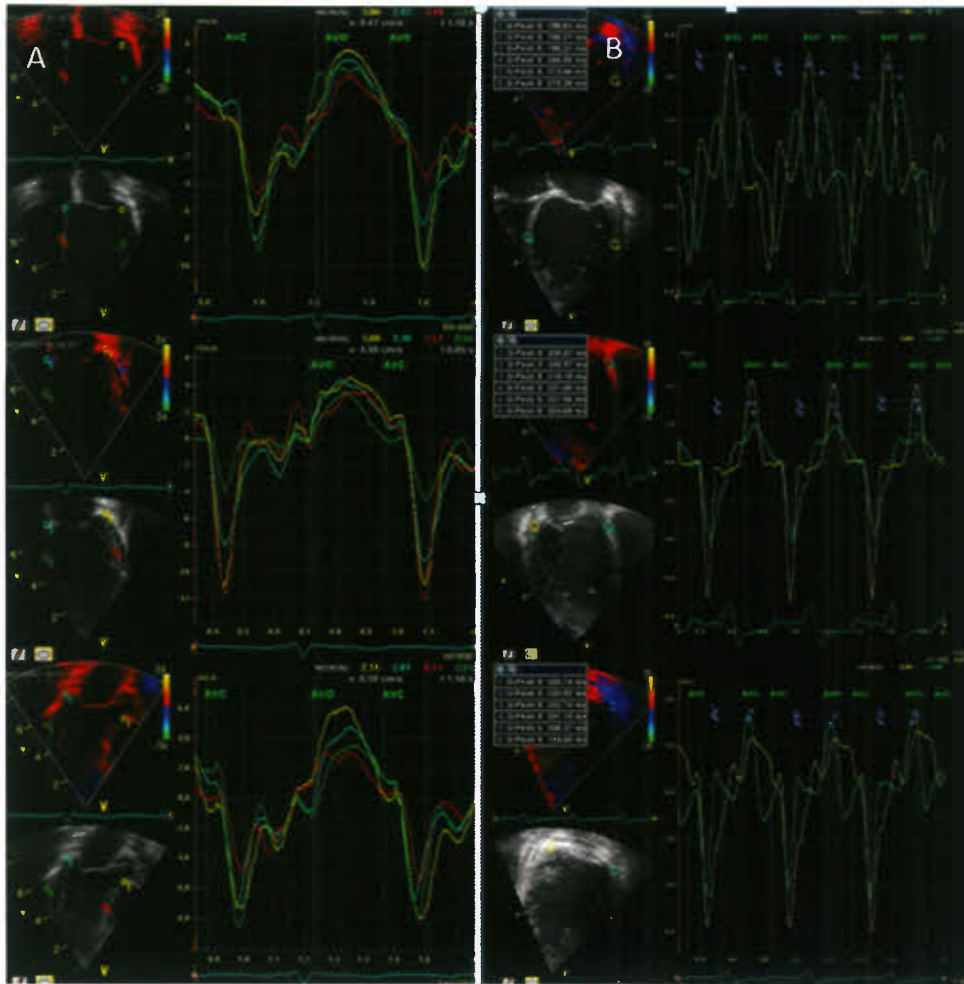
Assessment of left ventricular (LV) intraventricular dyssynchrony using tissue Doppler to measure the left ventricular dyssynchrony (Yu) index. Aortic valve opening and closing are marked by the *green lines* to delineate ventricular ejection. In panel A 12 tissue Doppler curves are obtained from the basal and mid regions from apical 4 (top), 2 (middle), and 3 (bottom) chamber views. The time to peak velocity is measured using the onset of the QRS complex as a reference point. The standard deviation of the time to peak velocity during ejection is measured as the dyssynchrony index. In this normal example, tissue velocities reach their peak nearly simultaneously so that the standard deviation of time to peak velocity curves is low. In contrast, panel B shows curves from a patient with dilated cardiomyopathy where different segments reach peak velocity at different times. This would increase the standard deviation of time to peak velocity and indicate LV intraventricular dyssynchrony. For the sake of clarity, only 6 of the 12 segments sampled are shown.
